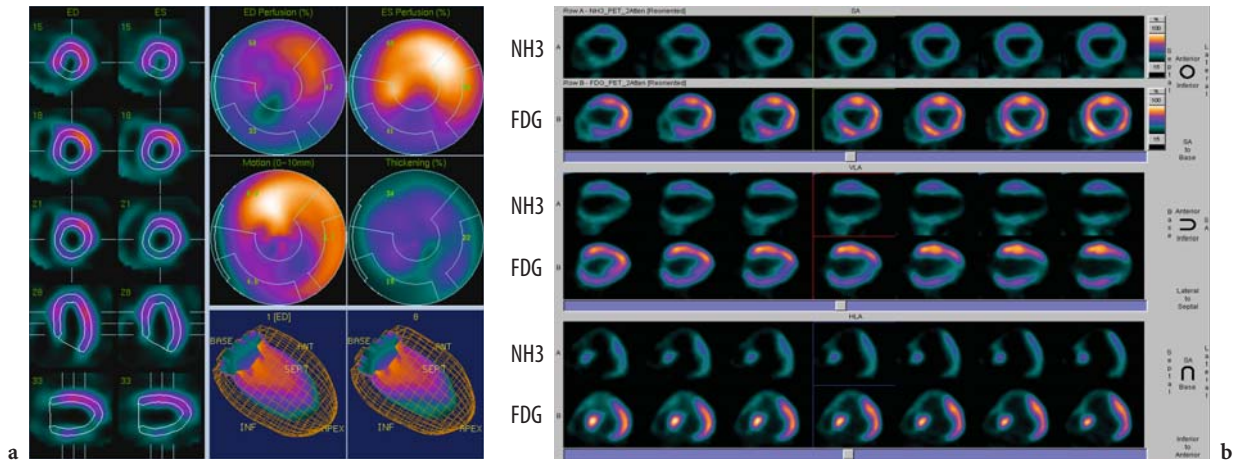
a Cardiac SPECT study displayed in short-axis view, long-axis view, bulls-eye plot, and 3D model reveals an infero-apical infarction with moderate peri-infarct ischemia. b Cardiac PET study with FDG and NH3 tracer radionuclides demonstrates a myocardial infarction of the posterior wall with a large area of necrotic myocardium. (Images courtesy of: a Page-Campbell Cardiology, Nashville, USA and b Cleveland Clinic Foundation, USA)
